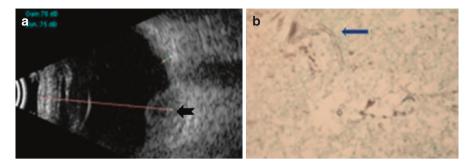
A 41-year-old man presented with decreased vision in right eye, 1 day following percutaneous transluminal coronary angioplasty. The affected eye right eye had anterior chamber hypopyon with dense vitreous exudates. Ultrasound B-scan revealed dome-shaped elevation arising from the choroid (*notched arrow*, a) (*left*). Three consecutive vitreous biopsies did not grow any organism. However, a subretinal biopsy, 1 month after initial presentation, revealed presence of fungal filaments (*arrow*, b). (*Right*) The patient was treated with intravitreal and oral voriconazole, but vision could not be salvaged (Courtesy: Rajeev K. Reddy, MD)
